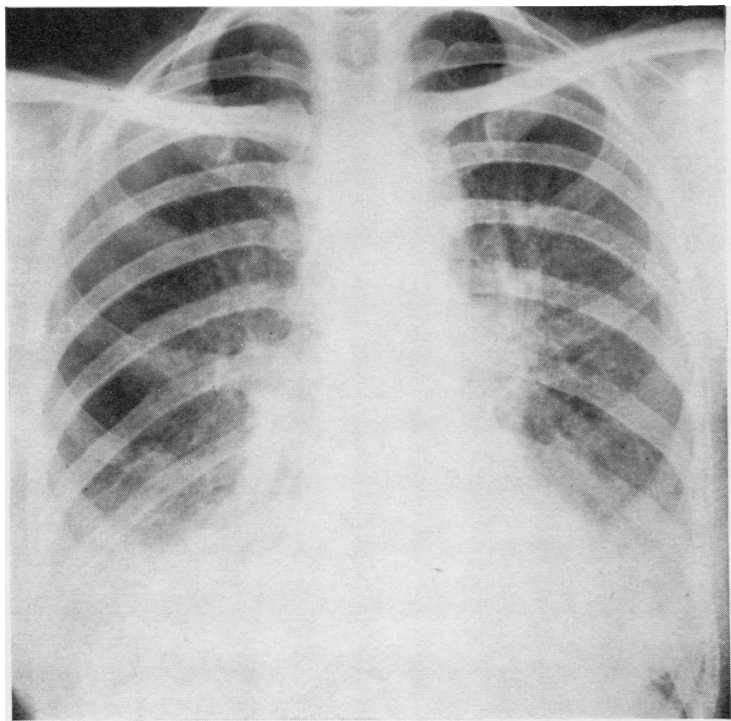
Radiograph of the chest of patient M.K., showing uniform shadows above the diaphragm with light mottling in most of the left and the middle zone of the right lung.
